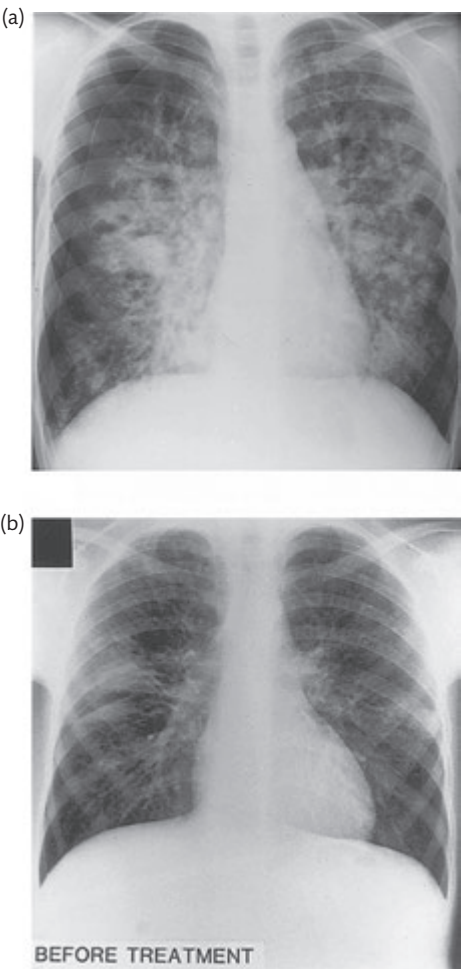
(a) The typical chest radiograph appearances of advanced cystic fibrosis lung disease. There is also a right pneumothorax. (b) The chest radiograph in an adolescent boy with cystic fibrosis complicated by allergic bronchopulmonary aspergillosis. Note the wedge-shaped shadow in the right mid zone.
